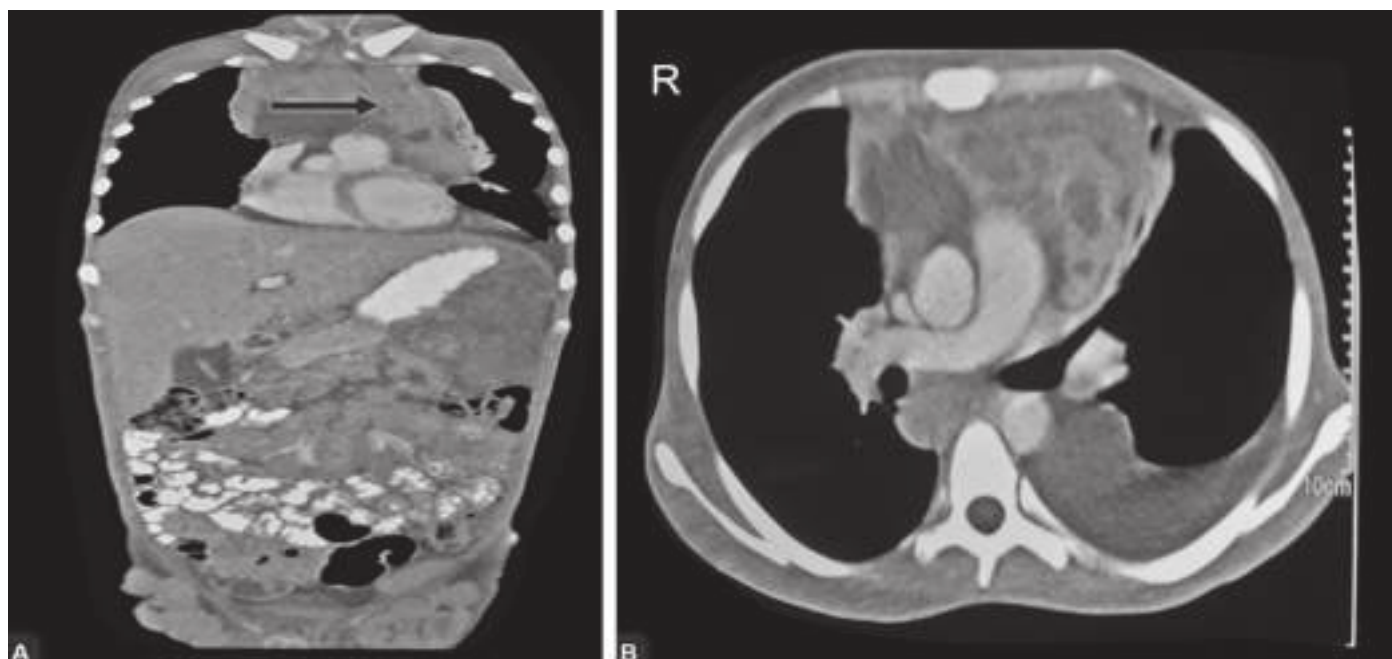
Mediastinal lymph nodes in acute lymphoblastic leukemia (ALL) on CT scan. Coronal image (A) and transverse image (B) on CT scan shows mediastinal mass in a case of T-ALL.
